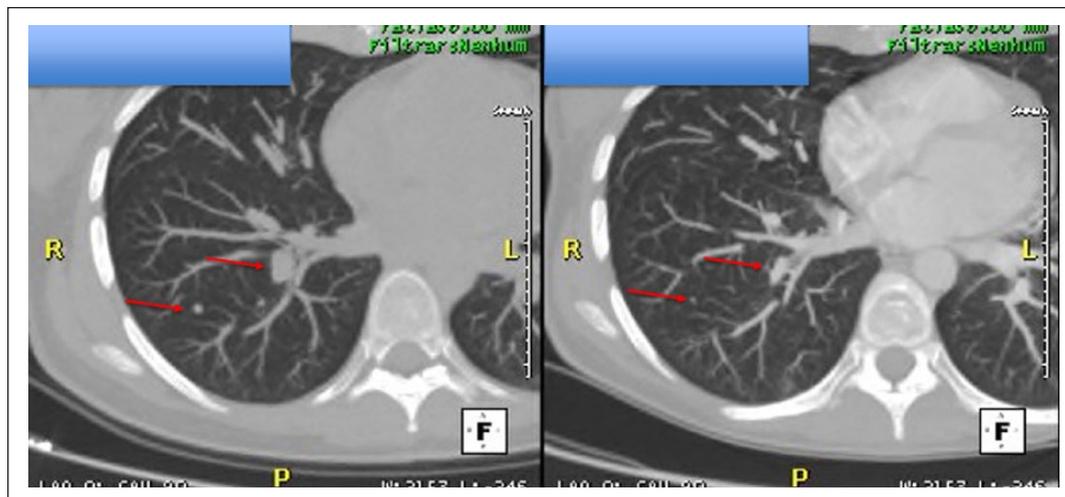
CT scan of the lungs showing reduction in the size of two right lung nodules.
